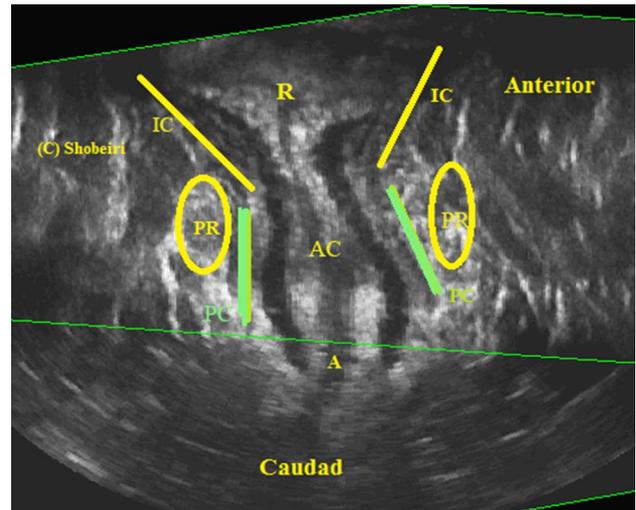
Coronal view of the anorectal canal obtained with 3D endovaginal ultrasound demonstrating a normal woman's anorectal funnel created by PC in green, PR (the yellow circles), and the IC fibers. A Anus, AR anorectum, D defect, IC ilioococcygeus, LAM levator ani muscle, PA puboanalis, PC pubococcygeus, PR puborectalis, PS pubic symphysis, T transducer, U urethra
